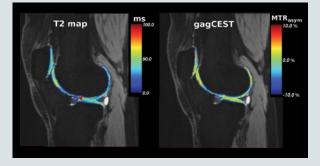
Example knee MRI scan (Acquired at the Herston Imaging Research Facility, Royal Brisbane and Women's Hospital). Two MRI protocols describing tissue biochemical properties (left: T2 relaxation time in milliseconds, right: gagCEST signal as percentage asymmetry of the magnetisation transfer ratio) are visualised in regions corresponding to the knee cartilage. Distribution of biochemical MRI signal can be used for quantitative assessment of tissue health and diagnosis of cartilage degeneration and other injuries.
